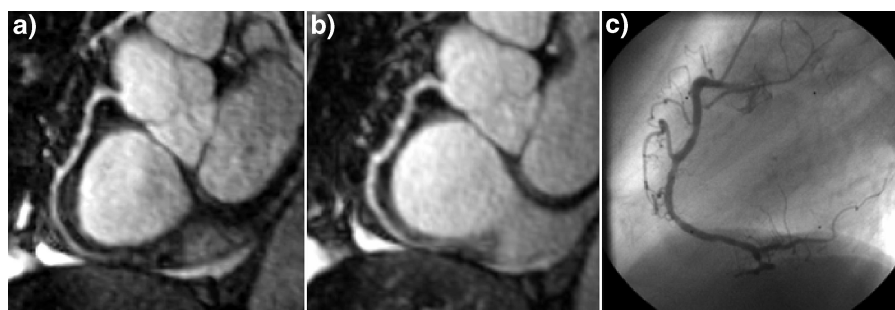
Comparison of MRCA and conventional X-ray angiography: a + b) MIP-images of the RCA before and after application of contrast agent (Gd-DTPA), demonstrating no significant change in image quality; c) corresponding conventional X-ray angiography.
